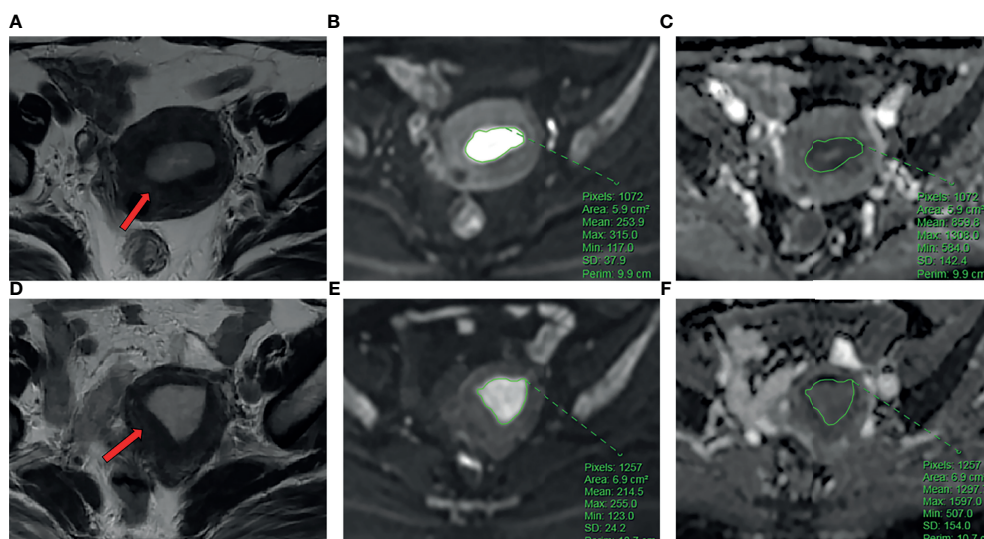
(A–C) The patient is a 54-year-old female with EC. Ki-67 expression was 70%, and p53 expression was positive. (A) Axial T_2 WI showed an irregular mass in the uterine cavity (arrow). (B) ROI of the largest lesion area on DWI. (C) The ADC values on ADC map. (D–F) The patient is a 58-year-old female with EC. Ki-67 expression was 60%, and p53 expression is negative. (D) Axial T_2 WI showed an irregular mass in the uterine cavity (arrow). (E) ROI of the largest lesion area on DWI. (F) The ADC values on ADC map.
